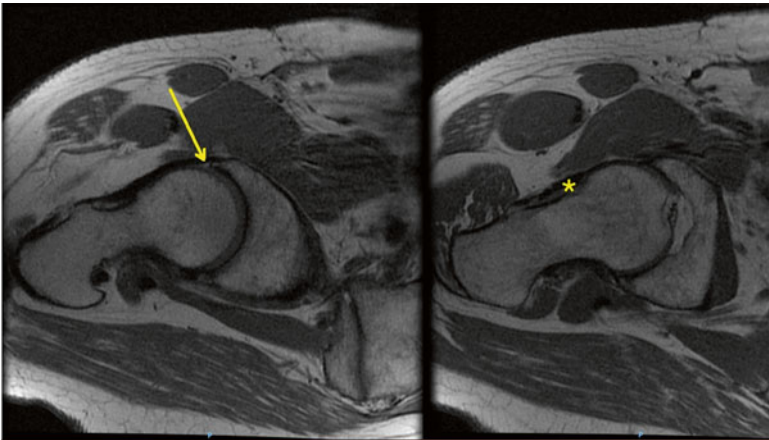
MRI of the pelvis, non-contrast, T2 axial view. Right anterior acetabulum with intermediate linear increased intensity signal, suggestive of labral tear (*yellow arrow*). Also, concomitant osseous bump at femoral head-neck junction suggestive of CAM-type femoroacetabular impingement (*yellow asterisk*). MR arthrogram is indicated.
